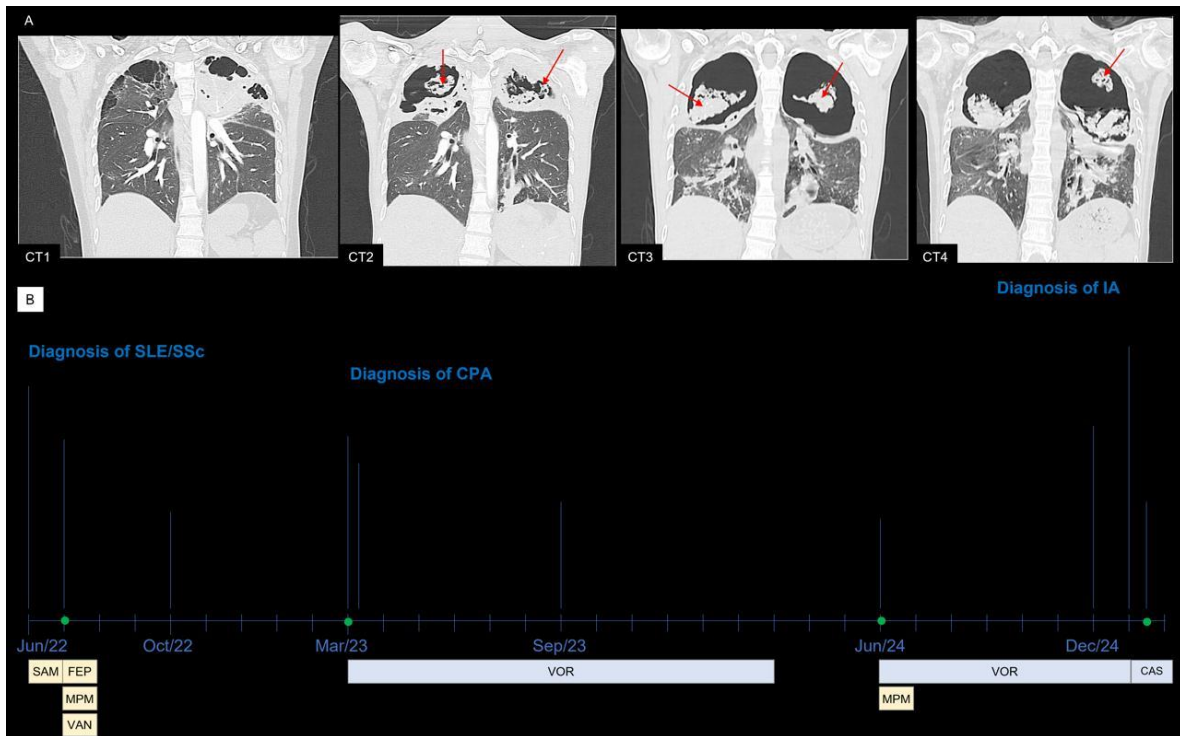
Computed tomography (CT) findings, and time course of diagnostic and therapeutic events. A. Evolution of CT features of pulmonary lesions at four different times from disease onset (green dots on the timeline). Volume loss in the upper lobes is observed. Consolidation and cavitation progression are evident over time. Round, hyperdense areas, suggesting fungal balls, are indicated (red arrows). Bronchial wall thickening and nodules are also observed. B. Timeline, per month, with the main events, including CT scans, and antibiotic and antifungal treatment in the clinical history of the patient. SLE: systemic lupus erythematosus; SSs: limited systemic sclerosis; HAP: hospital-acquired pneumonia; SAM: ampicillin-sulbactam; FEP: cefepime; MPM: meropenem; VAN: vancomycin; HRCT: high-resolution computed tomography; CPA: chronic pulmonary aspergillosis; GM: *Aspergillus* galactomannan; BAL: bronchoalveolar lavage; VOR: voriconazole; IA: invasive aspergillosis; CT: computed tomography; FBS: fiberoptic bronchoscopy; CAS: caspofungin; ICU: intensive care unit.
